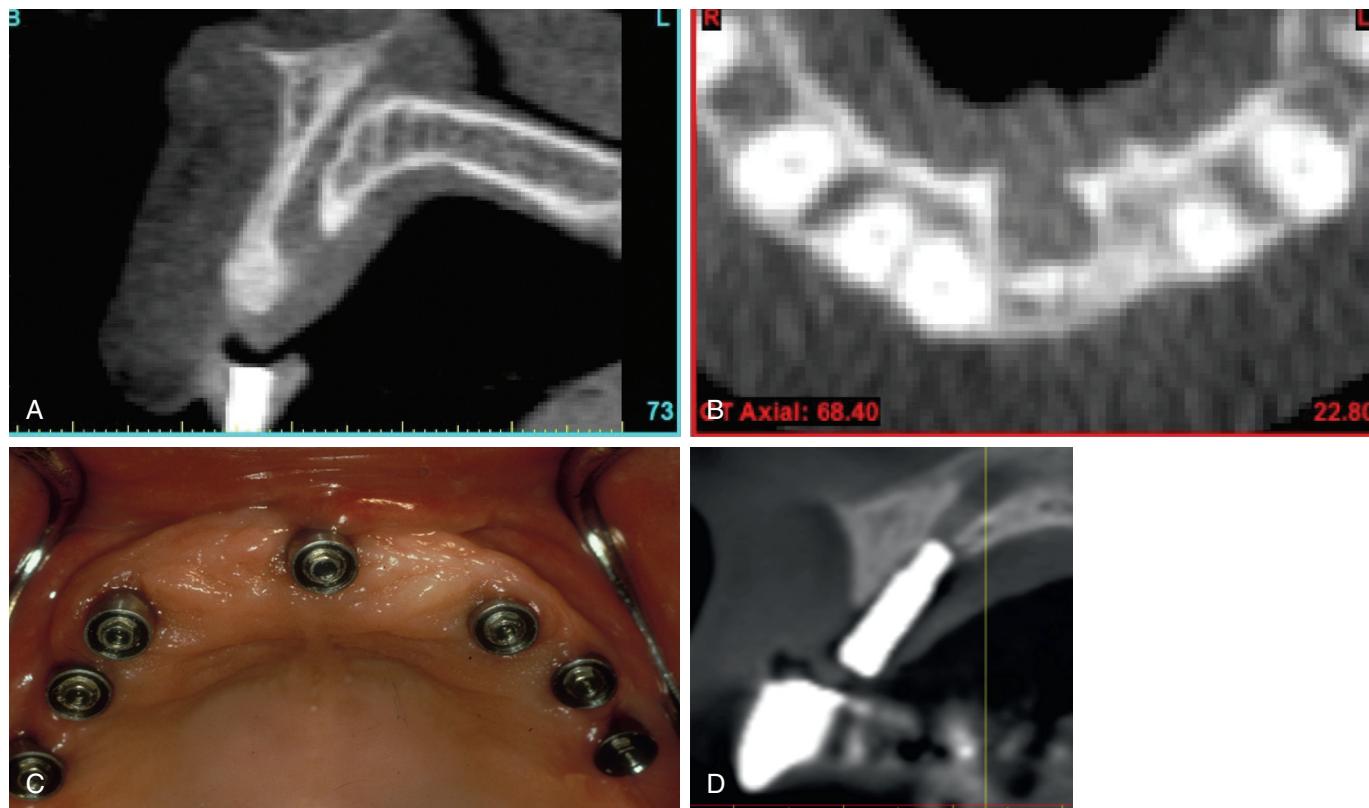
Nasopalatine nerve and canal. (A) Cross-sectional image depicting large nasopalatine canal. (B) Axial CBCT image. (C–D) Placement of implant into the nasopalatine canal after removal of soft tissue contents.
